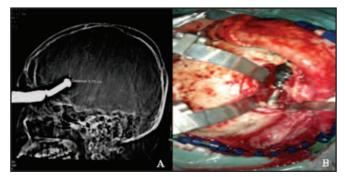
A: A Lateral CT Scanogram projection depicting the projectile penetrating the anterior cranial fossa.B: Intraoperative image depicting the projectile within the frontal lobe and surrounding contusions.
